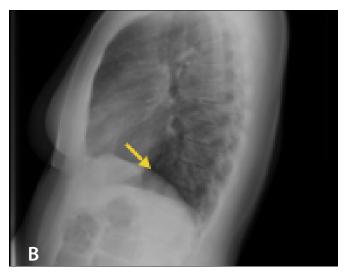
(B) Lateral view chest X-ray showing cysts (yellow arrow) in the lower zones.
